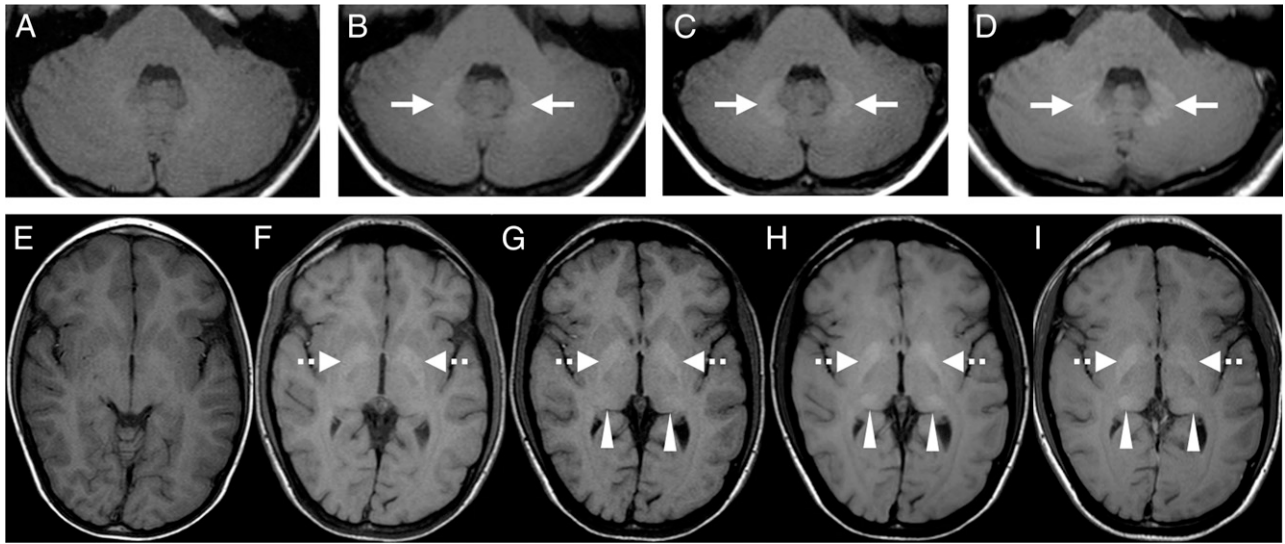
Precontrast T1 of the (A) first, (B) second, (C) third, and (D) 35th MRI showing progressive hyperintensity in the dentate nuclei (arrows). Similar images of (E) first, (F) 13th, (G) 14th, (H) 15th, and (I) 35th MRI of the globus pallidus (dotted arrows) and posterior thalamus (arrowheads).
